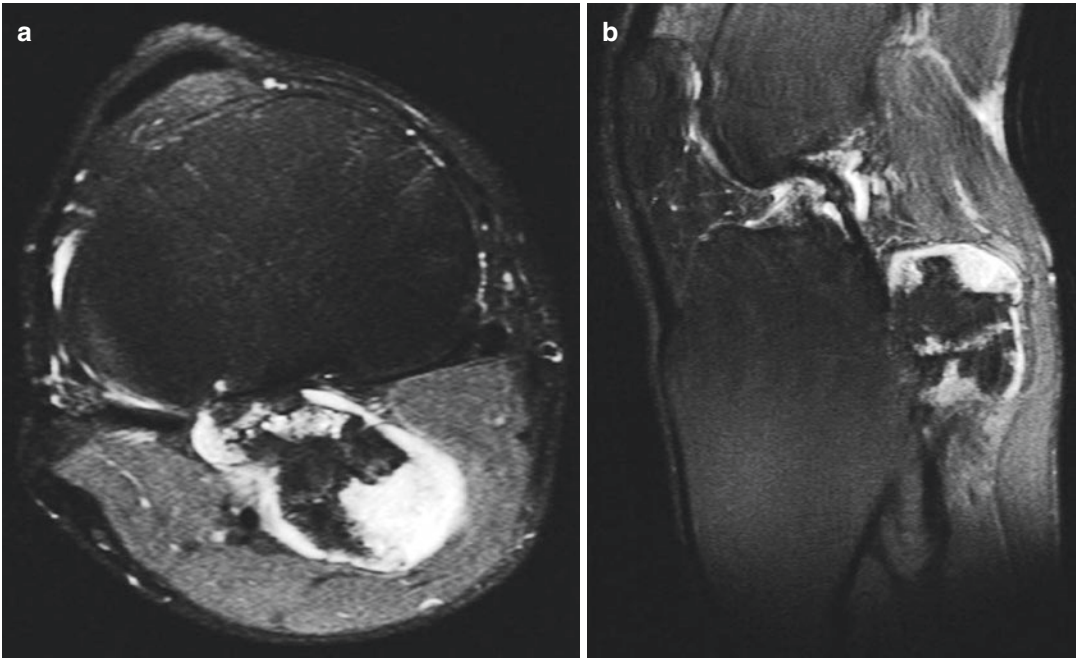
(a, b) Cartilaginous exostosis of the tibia in a patient with hereditary multiple exostoses syndrome. (a) Axial fat-suppressed T2-weighted MR image. (b) Sagittal
